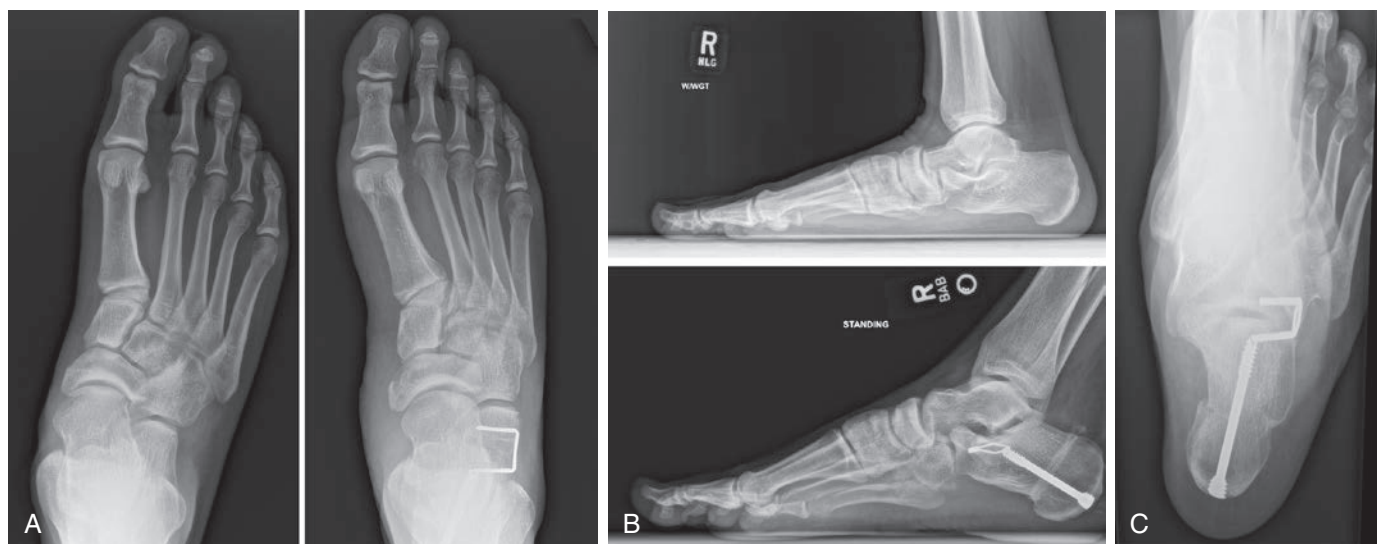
Radiographs of double calcaneal osteotomy to correct flatfoot, including medializing calcaneal osteotomy with compression screw fixation and lateral column lengthening procedure. (A) Pre- and postoperative anteroposterior views, (B) pre- and postoperative lateral views, and (C) postoperative axial view.
